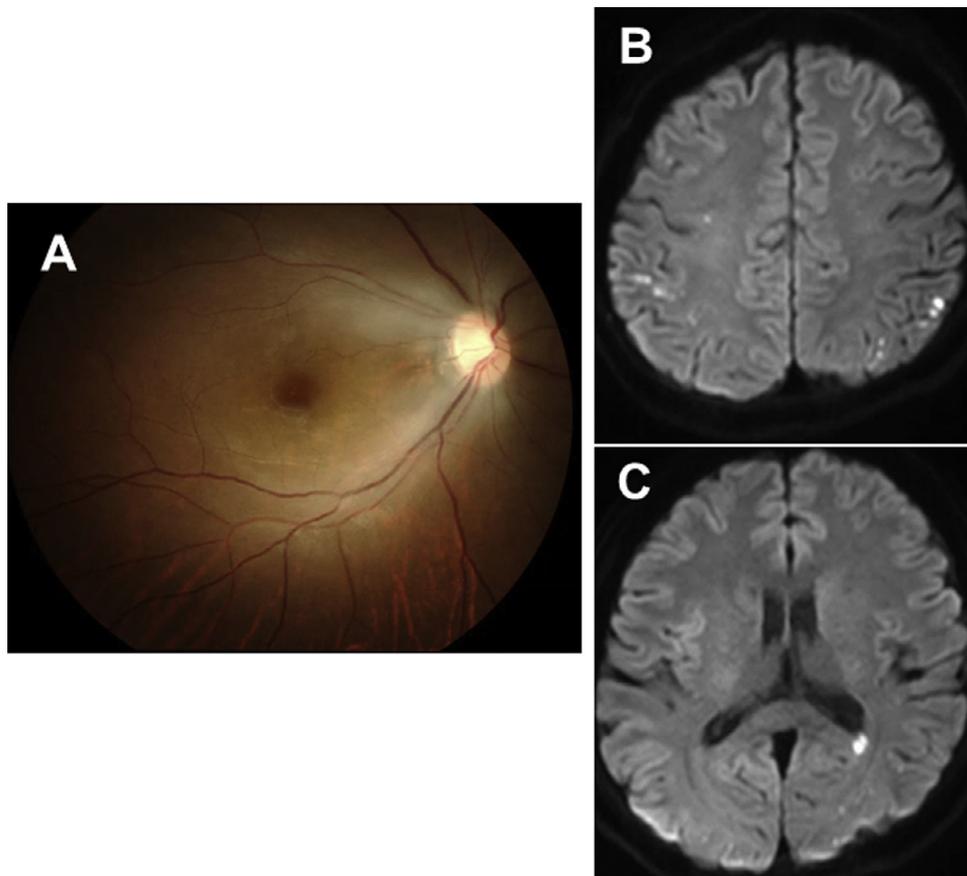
(A) Fundus examination of the right eye. Stenosis of the retinal arterioles and swelling of the retina are seen, indicating branch retinal artery occlusion. (B and C) Diffusion-weighted MRI of the brain. Acute multiple infarcts are observed bilaterally in the cerebral cortex, subcortex, and periventricular white matter, indicating an embolic mechanism.
